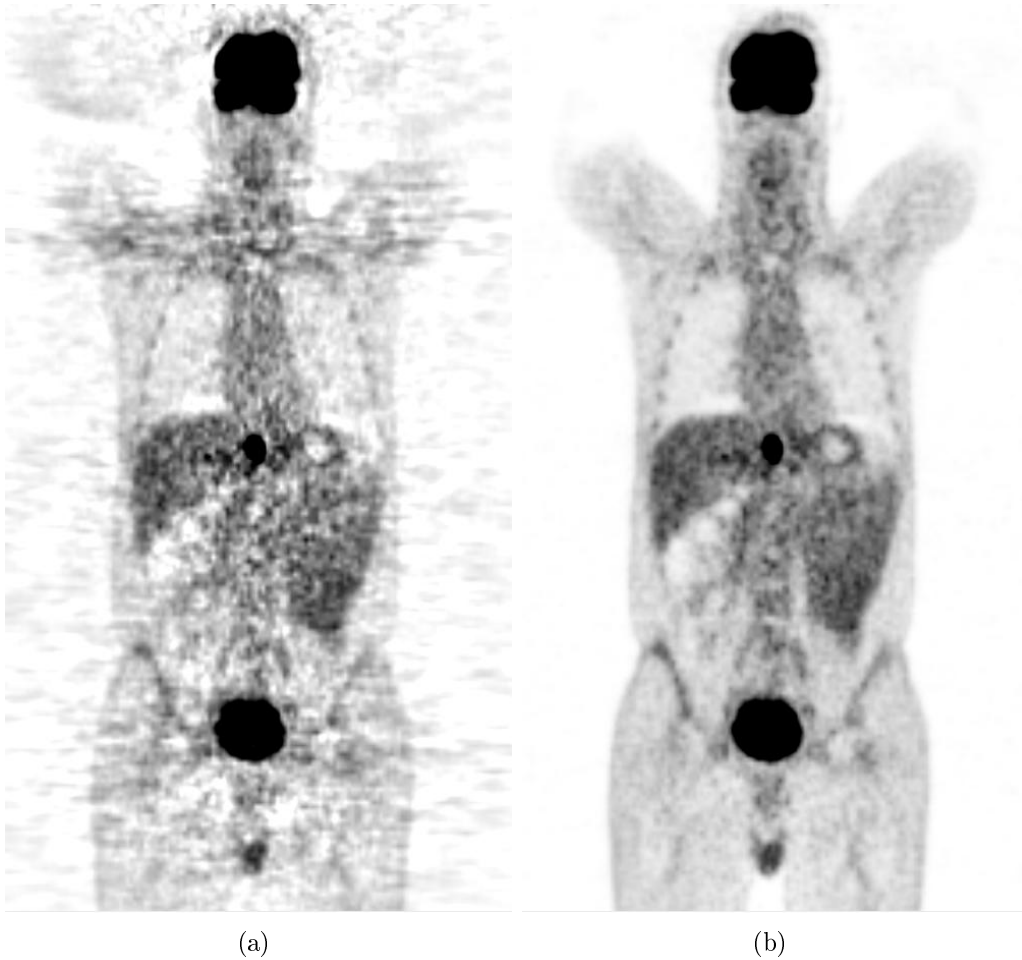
Coronal slice of a ^{18}F -FDG PET image reconstructed using the FBP (a) and the AW-OSEM (b) algorithm. The FBP reconstruction appears noisier, with streaking artifacts, and harder to interpret as compared to the OSEM reconstruction.
